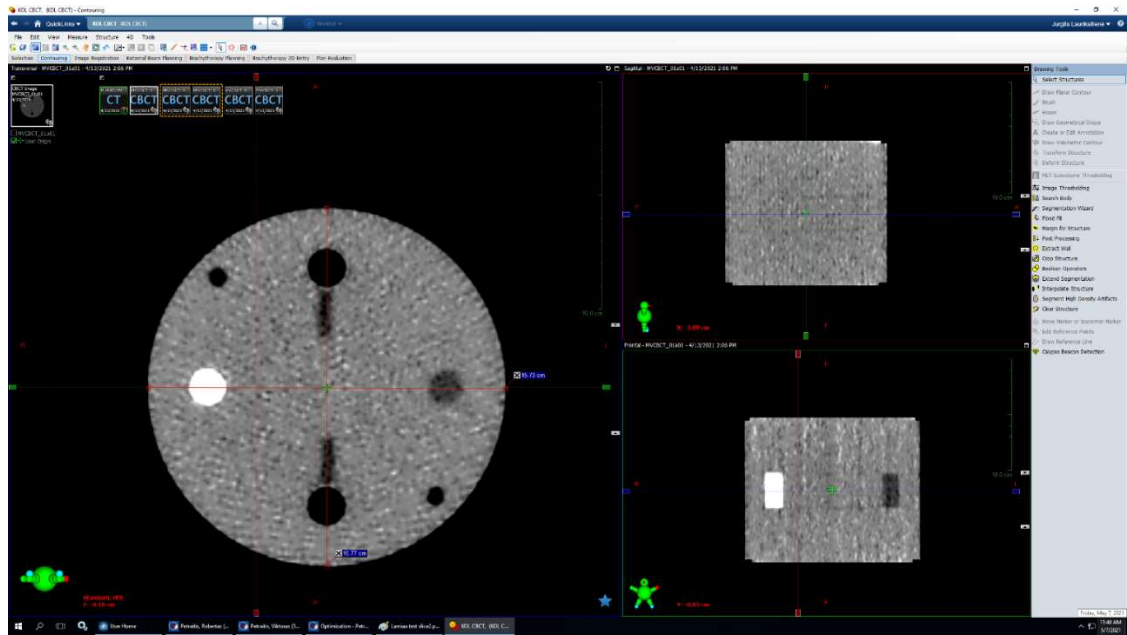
Central slice of CBCT reconstruction of visual slice thickness measurement geometric scaling measurement (Vertical).
